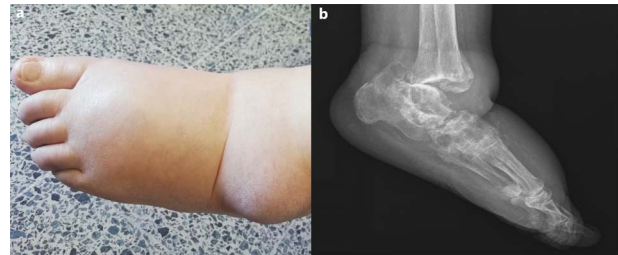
(a) A clinical image of a left foot deformity with complete dislocation of talus plantolaterally and (b) radiograph of a left foot showing tibiocalcaneal and talonavicular subluxation and cortical erosions.
